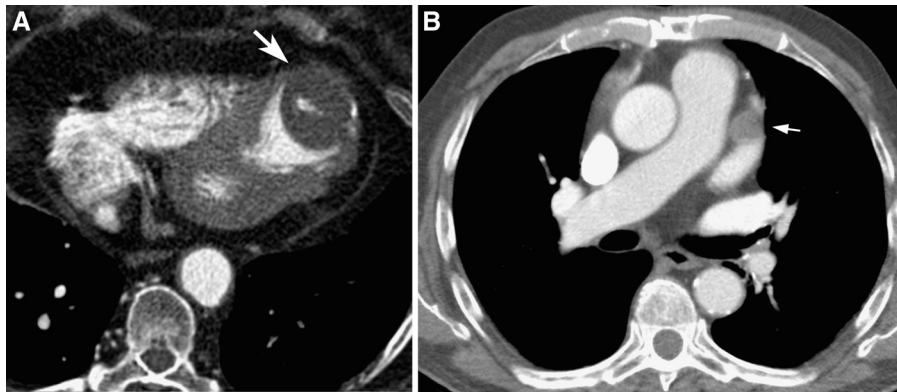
Intracardiac thrombus. (A) Axial contrast-enhanced computed tomography (CT) image, showing thrombus in the apex of the left ventricle with associated thinning and focal calcification of the apical myocardium from previous transmural infarction (arrow). (B) Axial contrast-enhanced CT, showing thrombus in the left atrial appendage (arrow) in a patient with known atrial fibrillation.
